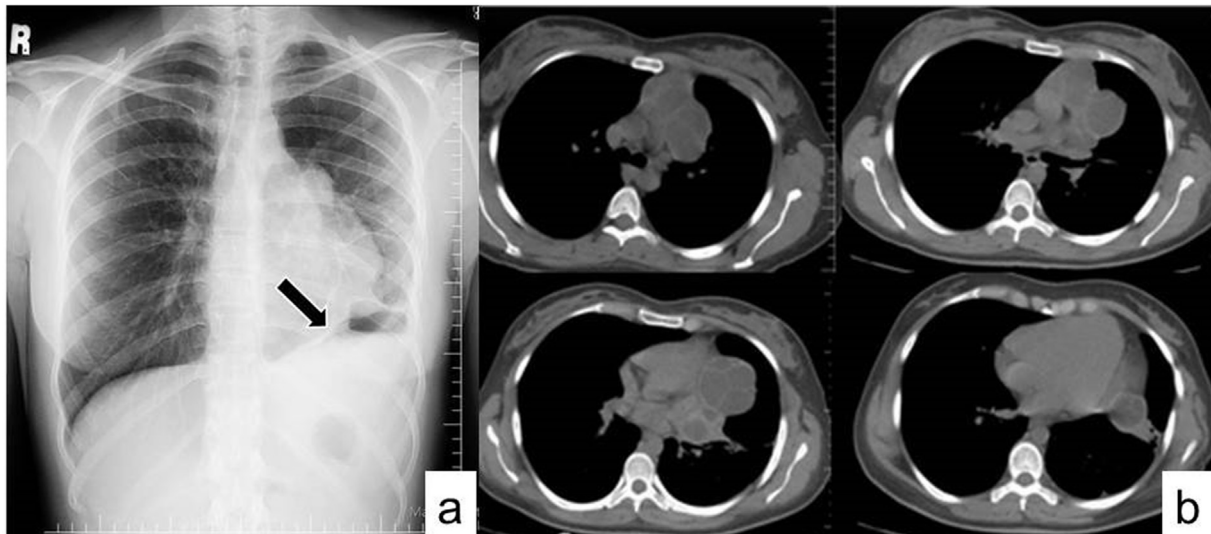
Chest X-ray shows left diaphragm is elevated (black arrow), cystic lesions at the left lower zone and adjacent to the mediastinum (a). Non-contrast thorax computed tomography axial images shows cystic lesions in the left lower lobe, adjacent to the left pericardium and adjacent to the upper mediastinum (b).
